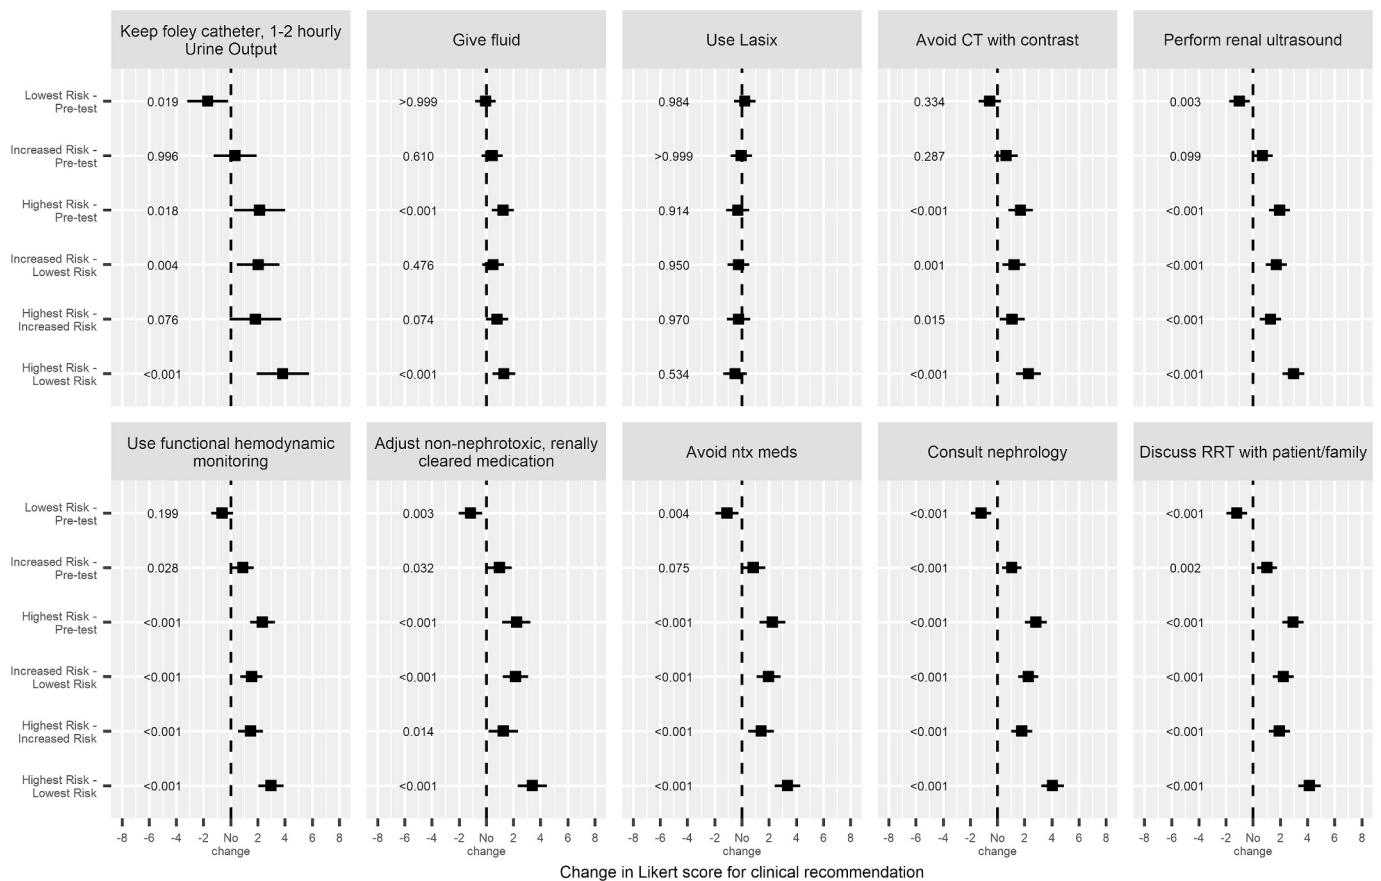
Change in Likert scores as a function of persistent stage 3 AKI risk for each clinical action. Change in the fitted Likert scores from mixed ordinal regression between the indicated pairs (y-axis) in the format, “A – B”, where “A” and “B” is one of the following: Pre-test, Lowest Risk, Increased Risk, and Highest Risk. The p-value (left of ■) is the probability that the change is zero (dotted vertical line). The x-axis is in units of Likert scores where a negative number denotes a Likert score for “A” that is lower than that for “B” in the pair, and a positive number denotes a Likert score for “A” that is higher than that for “B”. For example, the recommendation to perform a renal ultrasound was significantly different from the pre-test condition when the CCL14 result indicated lowest risk (more against) with a p-value of 0.003; and in the opposite direction when CCL14 indicted highest risk (more in favor) with a p-value < 0.001.
